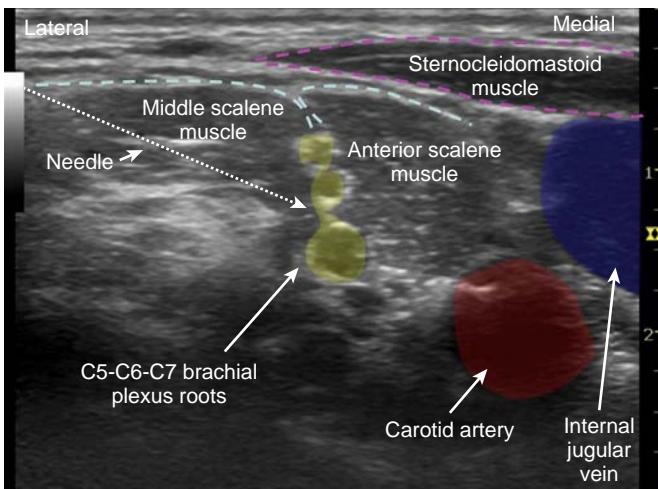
Ultrasound interscalene block imaging.
